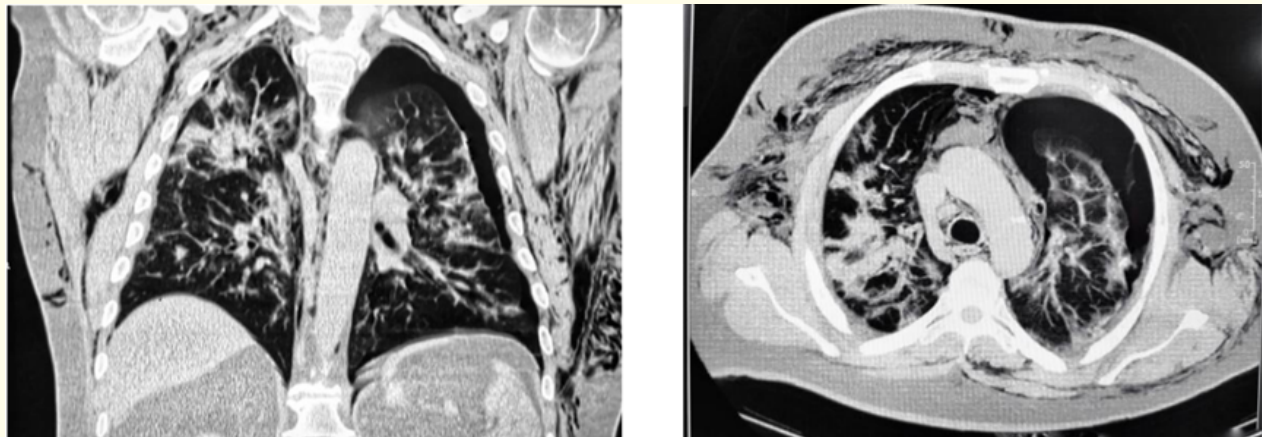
CT chest: Pneumothorax of the left lung with pneumomediastinum and extensive subcutaneous emphysema.
